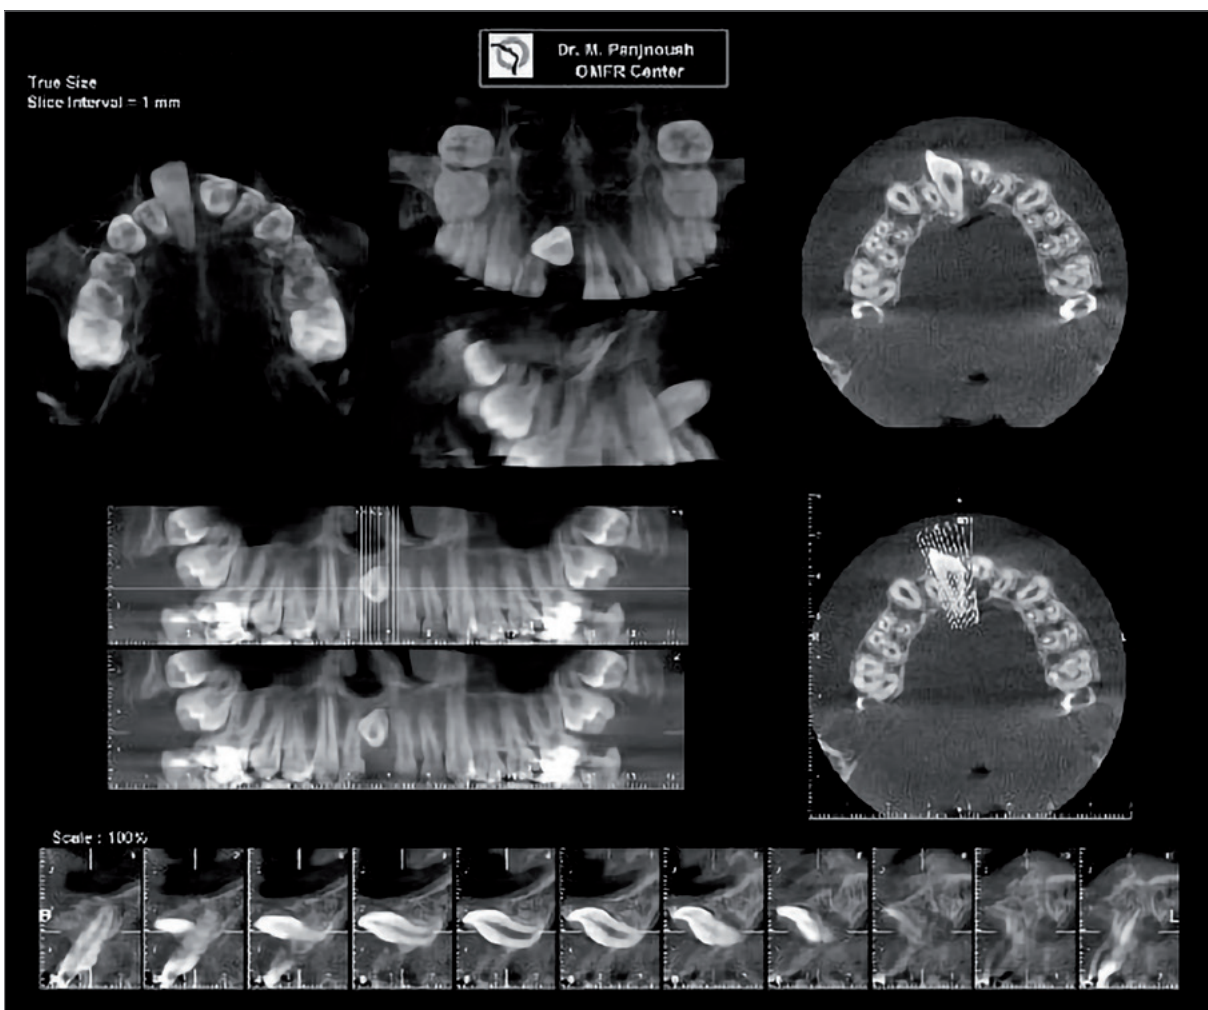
CBCT scan revealing impaction of the maxillary right central incisor.
